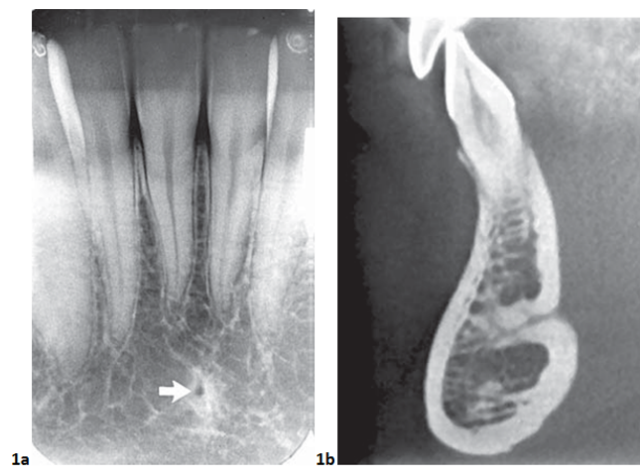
a: Lingual foramen on an intraoral periapical view (arrow), in the midline of mandible below the lower incisor apices. b: Cross-section CBCT image of anterior mandible shows lingual foramen extending deep into mandible from lingual surface
